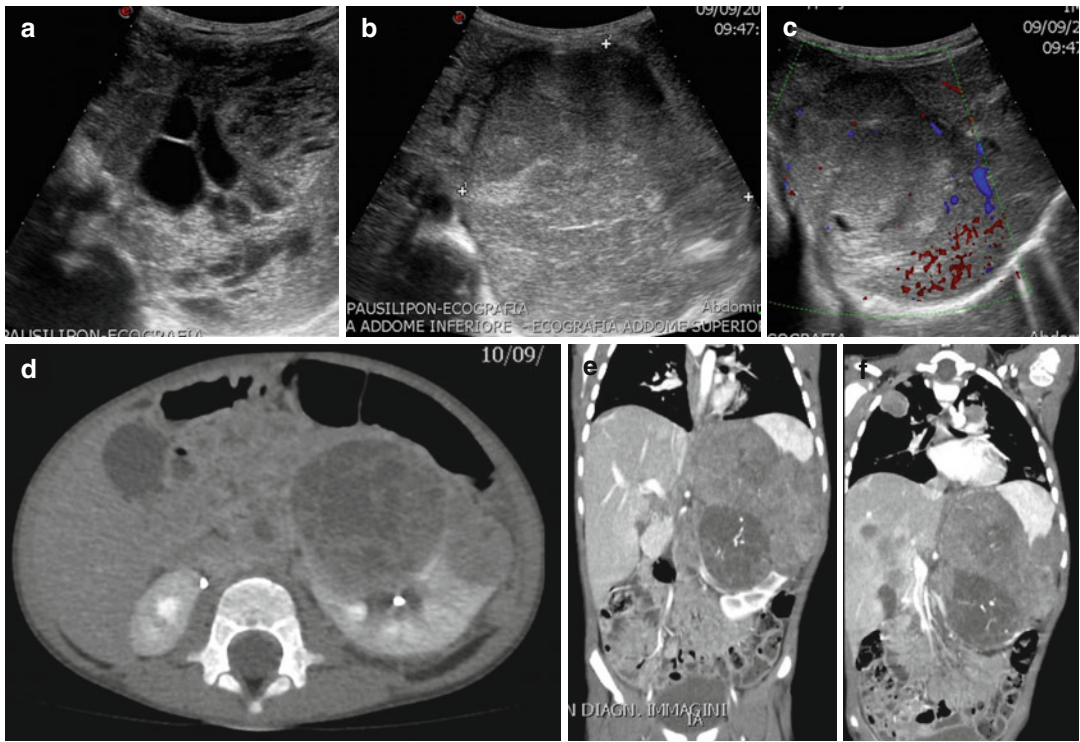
Female, 5 years old with malaise and pain as presenting symptoms. Wilms tumour of the left kidney. US appearance (a–c): a heterogeneous echogenicity mass with necrotic areas inside. CT on axial scan (d) and MPR
